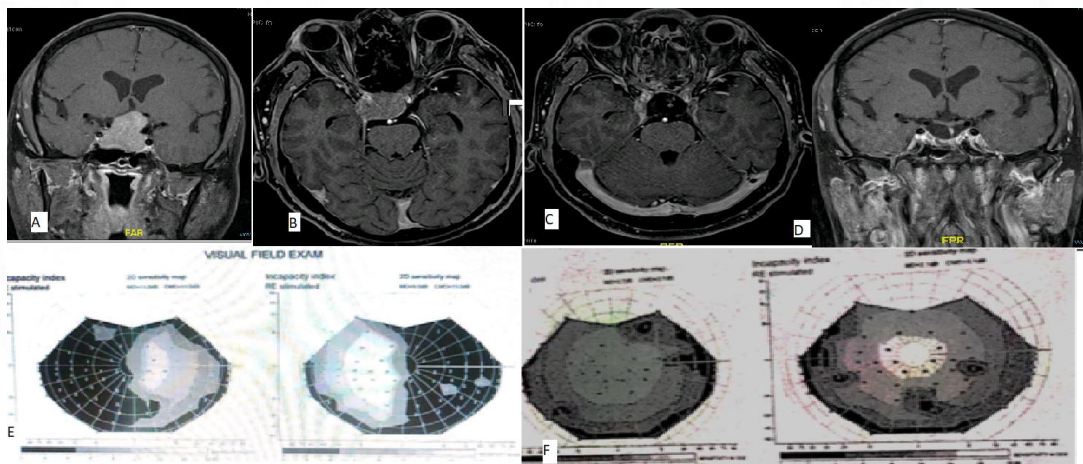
Preoperative and postoperative MRI images of brain with visual field testing. A- Coronal T1 contrast MRI showing contrast enhancing pituitary macroadenoma. B- Axial T1 contrast showing pituitary macroadenoma. C- Post operative axial T1 contrast MRI at 6 months showing no residual lesion. D- Post operative coronal T1 contrast MRI showing at 6 months no residual tumor. E- Preoperative visual field testing showing bitemporal hemianopia. F- Postoperative visual field
